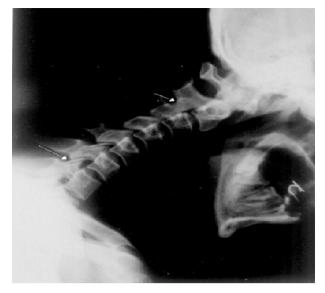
Lateral view radiograph of cervical spine in flexion in a 45 year old patient who has had PSA for 16 years. Apophyseal (Facet) joint fusion can be seen at C2–C3 and narrowing can be seen at C6–C7 (arrows).
